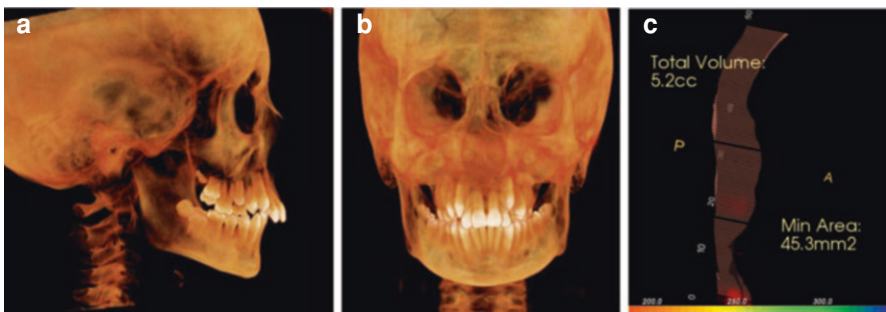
CBCT 3D reformations demonstrate the overall morphology of the craniofacial complex in addition to the size of the jaws in the anteroposterior (a) and transverse (b) dimensions. (c) Shows the airway dimensions of this patient. With smaller jaws, the space available for the tongue in the oral cavity is limited, and the tongue tends to reposition posteriorly, narrowing the oropharyngeal airway
